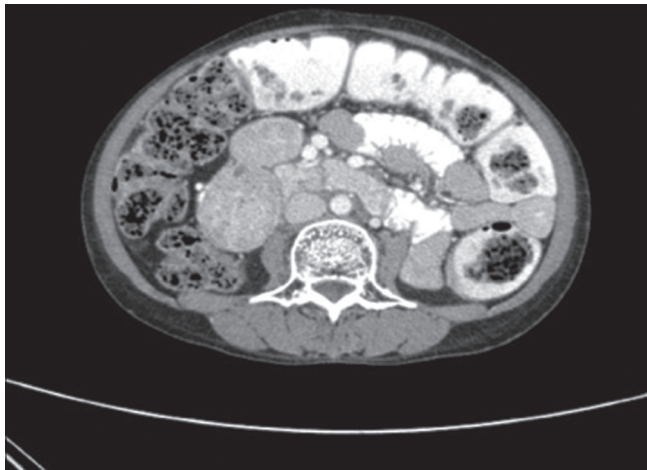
Computed tomography abdomen showing two well-defined, oval-shaped masses measuring 48 mm × 41 mm and 30 mm × 32 mm, interconnected with each other, inferior to the head of pancreas
